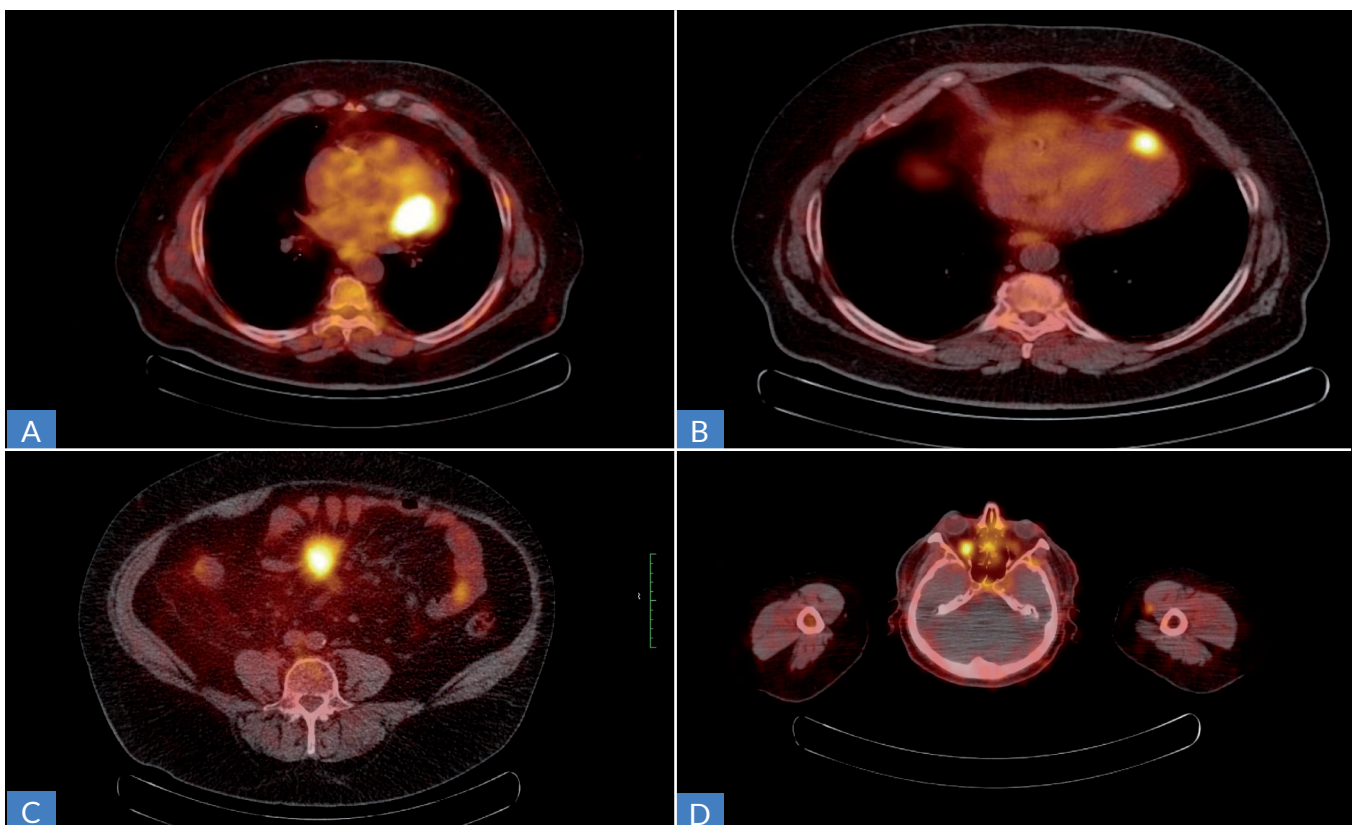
^{68}Ga -PET/CT. Overexpression of somatostatin receptors. A, B. Two focal lesions in the myocardium. C. A focal lesion in the mesentery of the small intestine. D. A focal lesion in the right orbit
